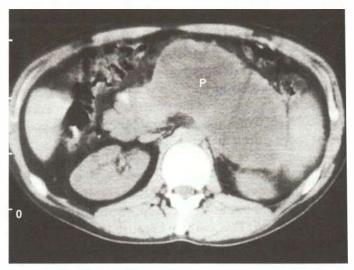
CT scan showing infected necrosis
